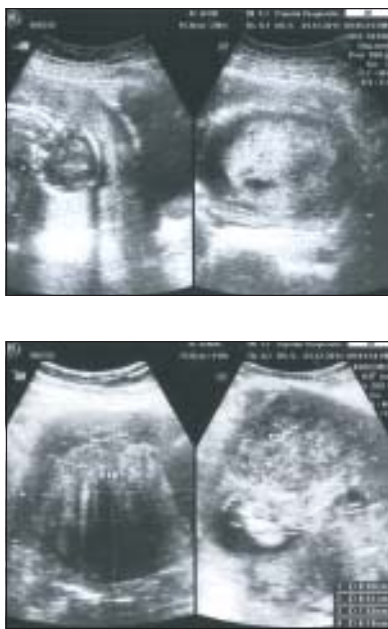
Ultrasonography showing multiple fibroid with 16 weeks of pregnancy in this patient.
